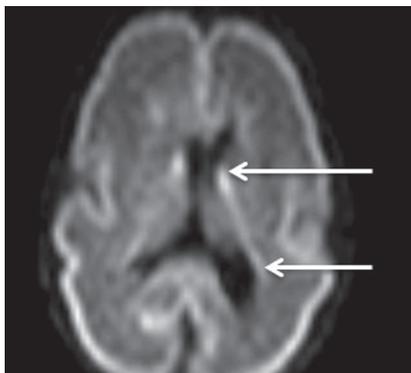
MRI of preterm newborn (PCA 28 wks.), DWI, axial plane. Hyperintense MR-signal from the germinal matrix in the projection of the external parts of lateral ventricles (marked by arrows)
